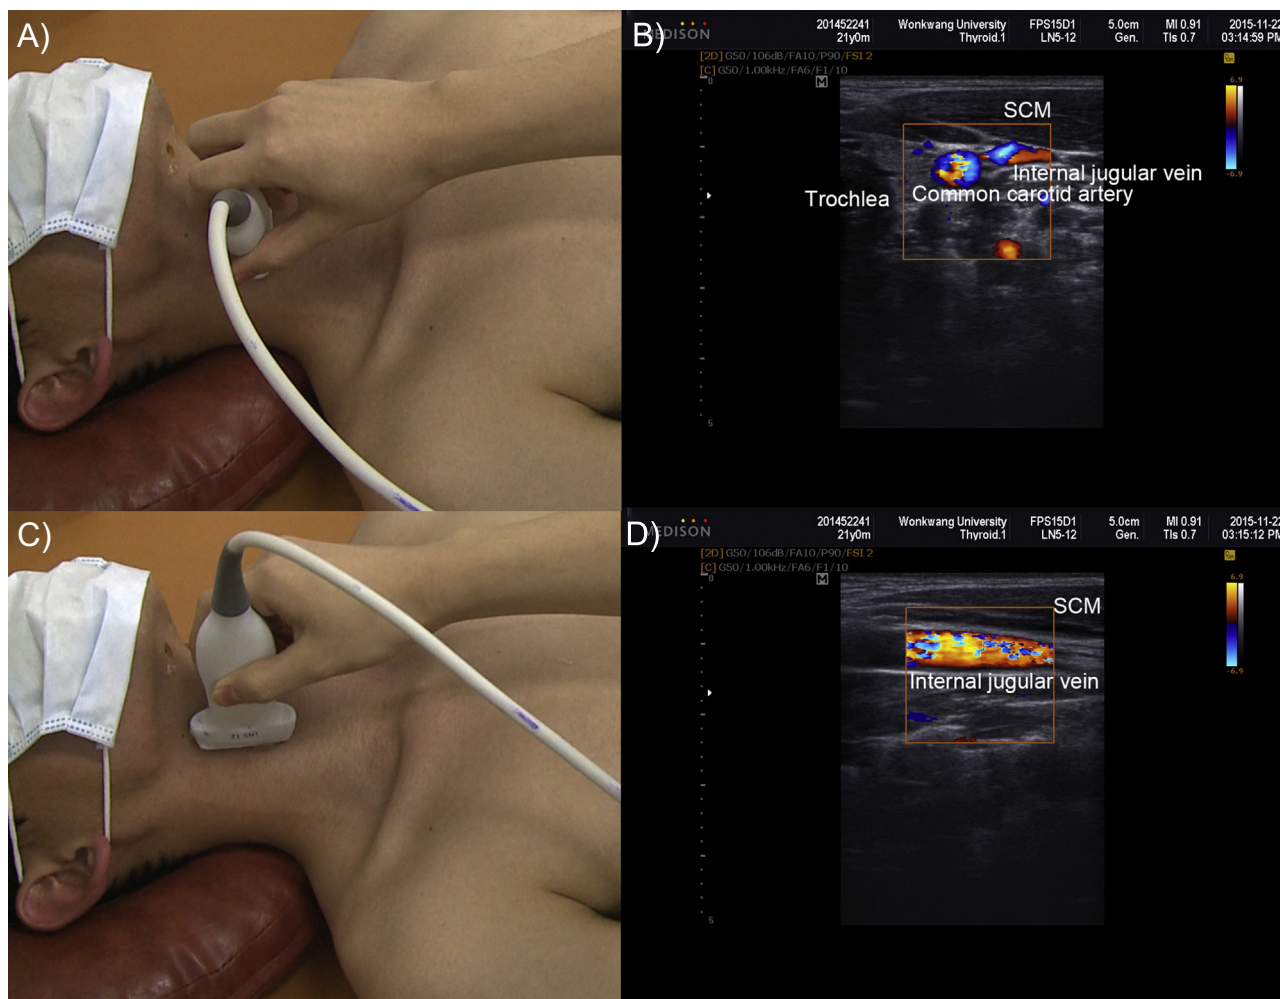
Examples of collecting ultrasound images for the acupuncture point ST9. (A) and (B) The probe direction is in the transverse plane according to anatomical position, and perpendicular to the surface. (C) and (D) The probe direction is in the axial plane according to anatomical position, and perpendicular to the surface. SCM: Sterno-Cleido-Mastoid muscle.
